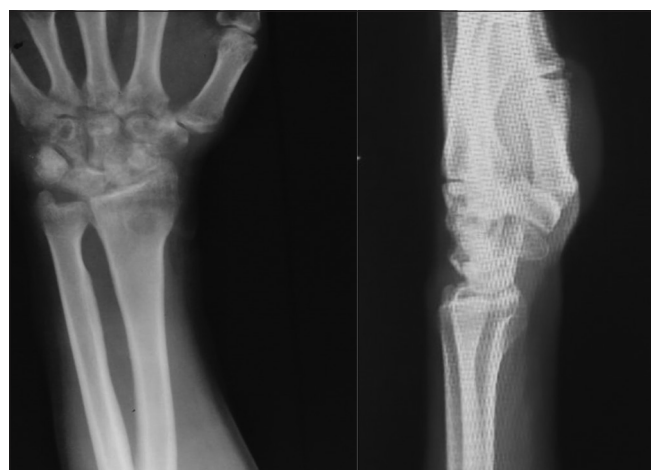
Radiograph at 6 weeks post-operative after K wire removal showing unition fracture
